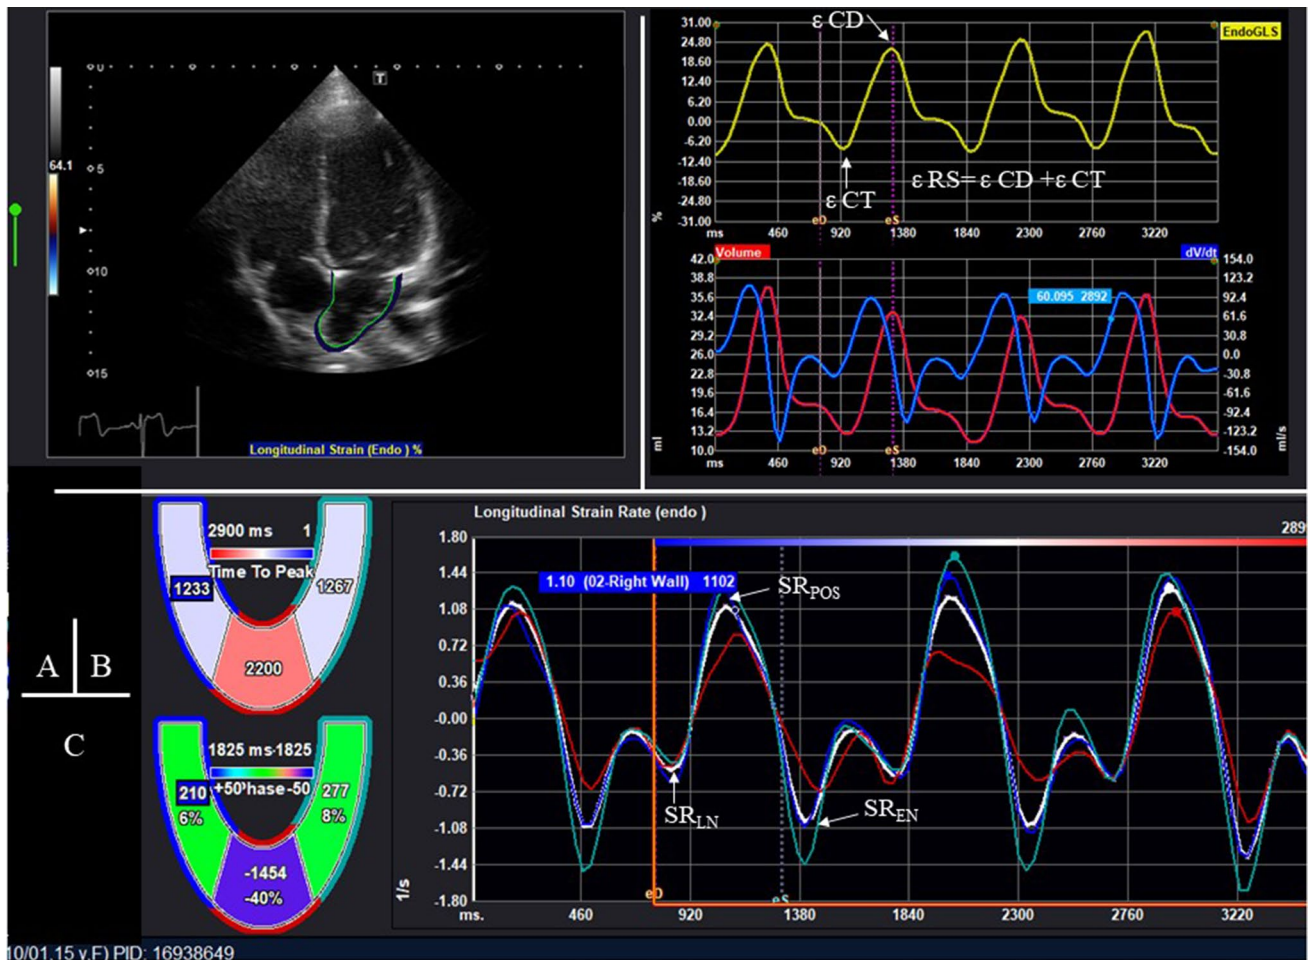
LA functional analysis using the 2D speckle tracking method obtained from an apical four-chamber view. a Two-dimensional images obtained from the apical four-chamber view were acquired for analysis. Three points (septal and lateral corners of the mitral annulus and LA roof) were plotted manually using a point-and-click technique followed by automatic tracing of the endocardial LA borders. The epicardial line was created as the region of interest which was divided into the following regions: lateral wall, medial wall, and roof.
